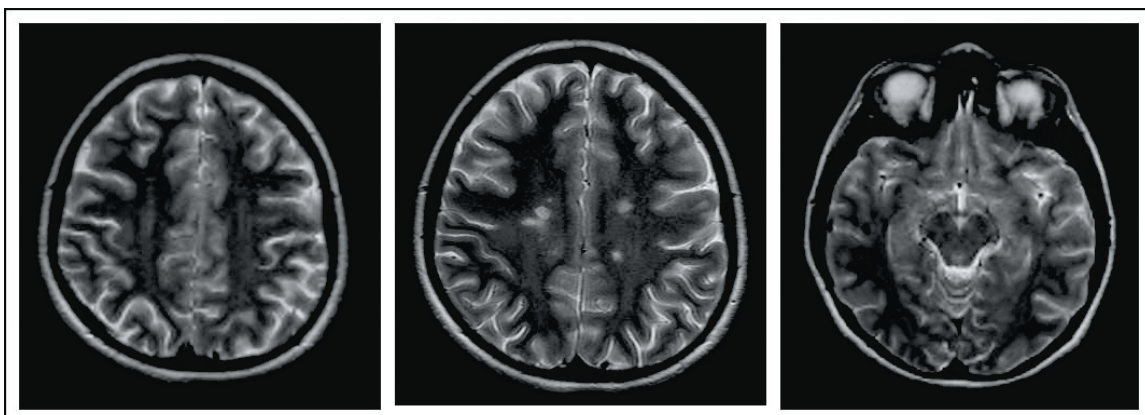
Initial brain MRI scans showed abnormalities with few demyelinating lesions in the periventricular, perpendicular to the lateral chambers suspected for MS
